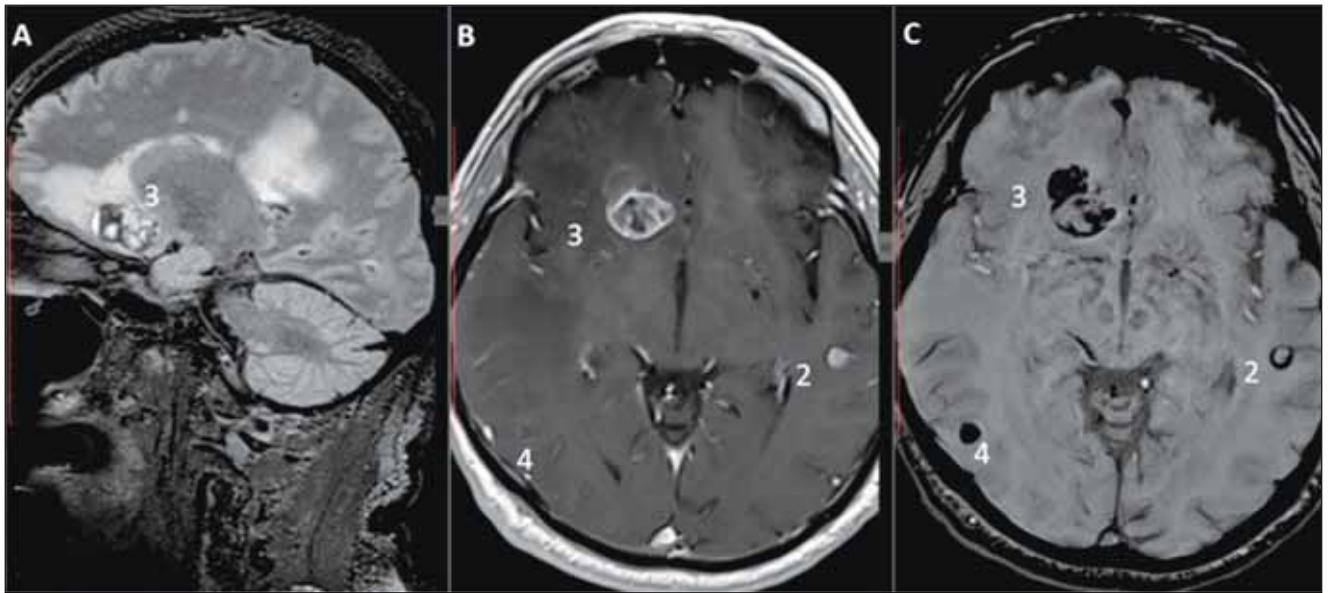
A – FLAIR, B – T1 + contrast, C – SWI. Lesion no. 3 located in the right frontal lobe shows high FLAIR, low SWI signal and ring CE and contiguous hematoma with a fluid-blood level on FLAIR sequence. Lesion no. 4 is seen in the right temporal lobe and shows marked SWI signal loss, T1 hypointensity with small ring CE. Lesion no. 2 is seen in the left temporal lobe with normal central SWI signal and peripheral rim signal loss and marked CE.
